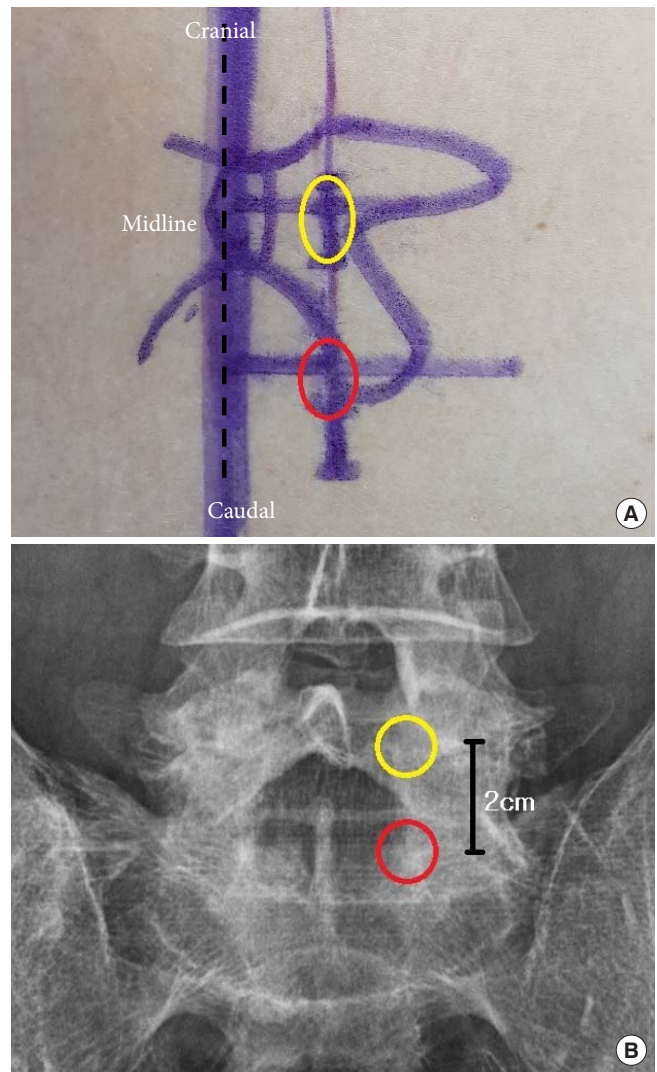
Initial placement of two portals and related anatomy. (A) Skin marking for the placement of 2 portals. (B) Position of 2 portals on anteroposterior view of X-ray. Yellow circle: the site for placement of cranial portal. Red circle: the site for placement of caudal portal.
